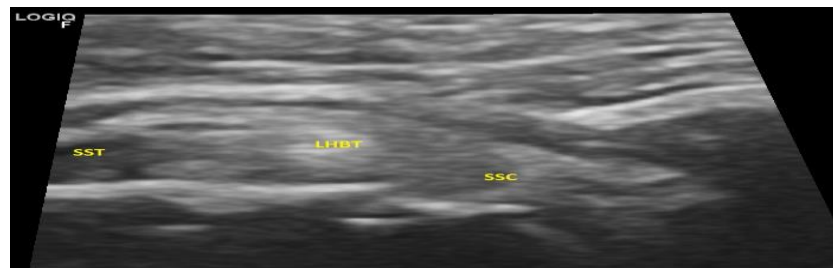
Ultrasound image of patient with adhesive capsulitis showing abnormal soft tissue in rotator interval. SST: Supraspinatus, LHBT: Long head of biceps tendon, SSC: Subscapularis.
